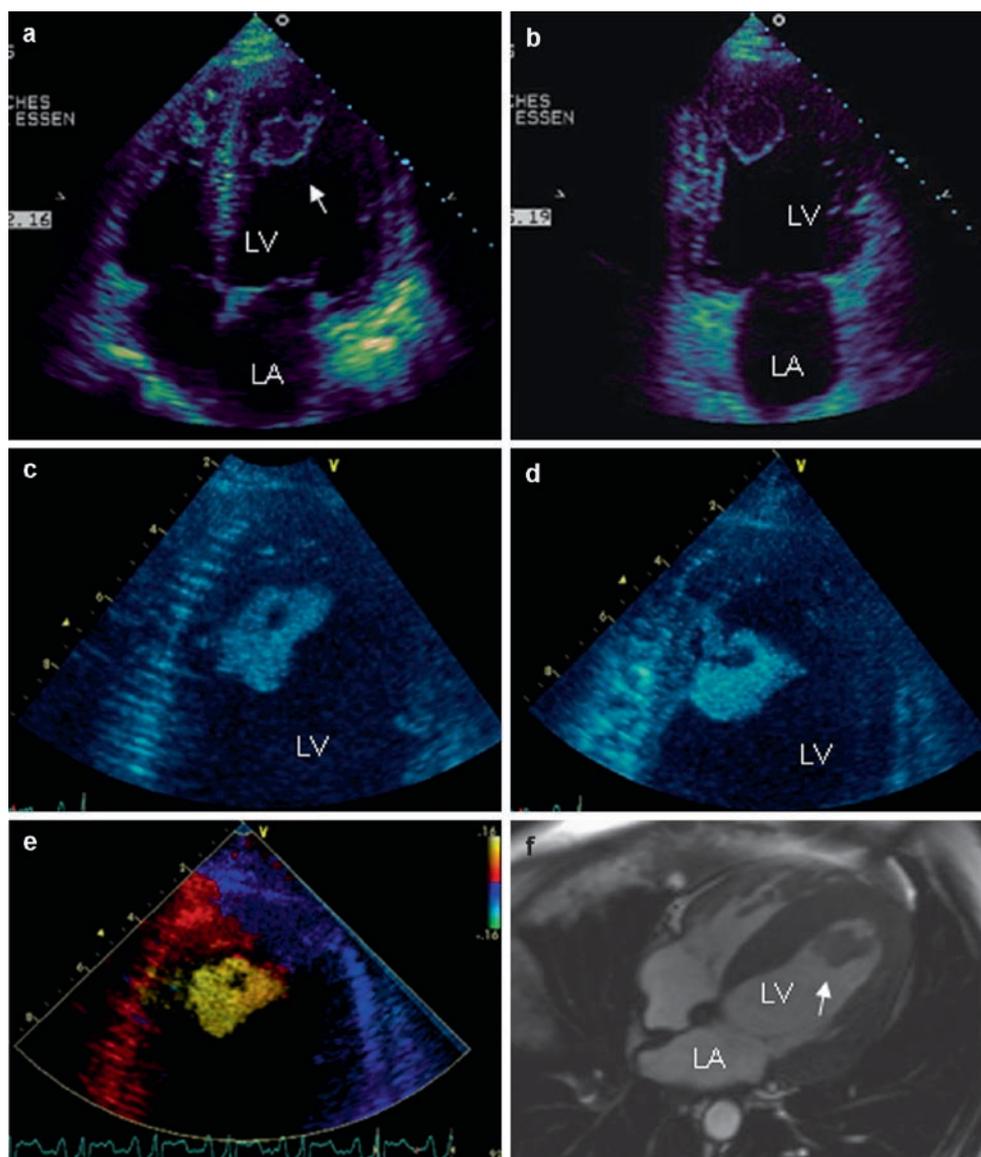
Large thrombus formation in an apical left ventricular aneurysm in a 54-year-old male patient after apical myocardial infarction. Transthoracic echocardiographic imaging (a) shows a large immobile thrombus (asterisk) with heterogeneous appearance
